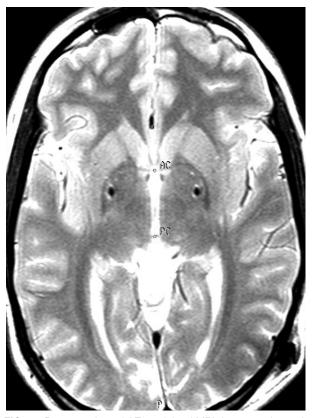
Postoperative axial T2-weighted MRI demonstrating typical bilateral GPi positioning of deep brain stimulation leads in a 24-year-old patient, positive for the *TOR1A* mutation (previously *DYT1*), with generalized dystonia who experienced a 60% improvement in BFMDRS movement score 6 months after surgery.
